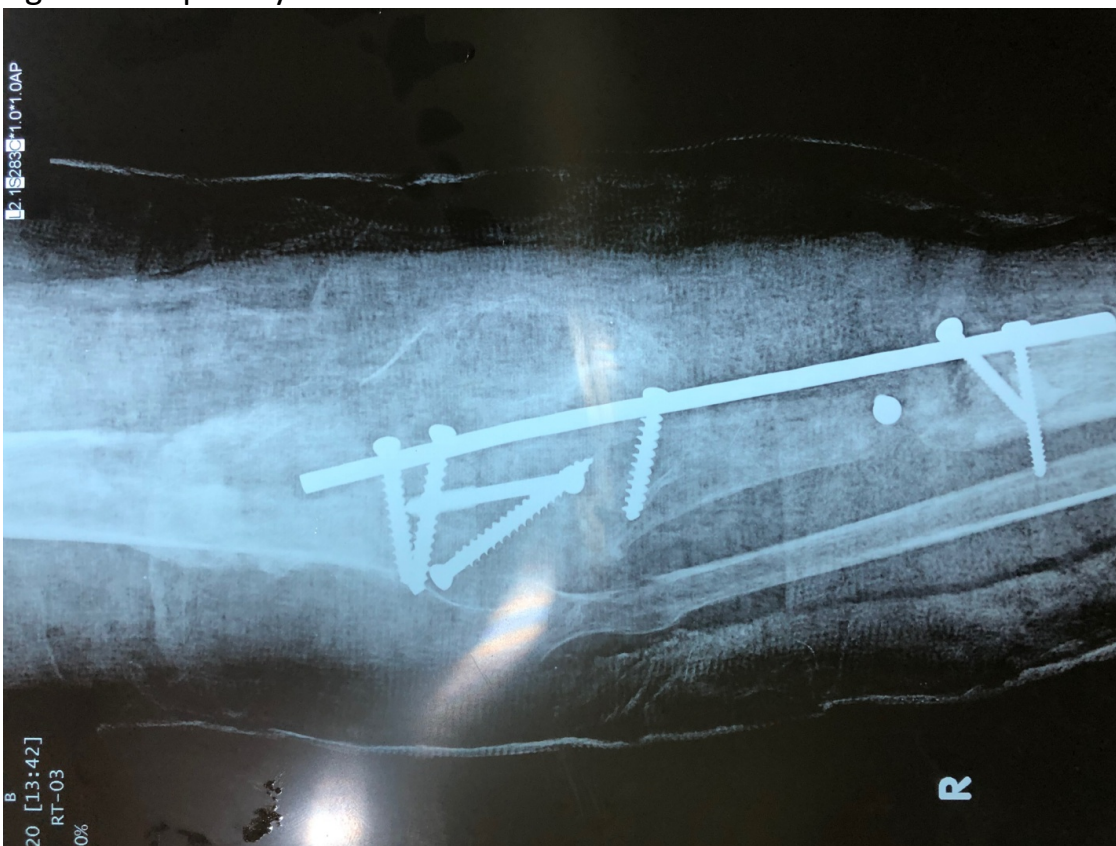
Post op X-rays at 3 months
